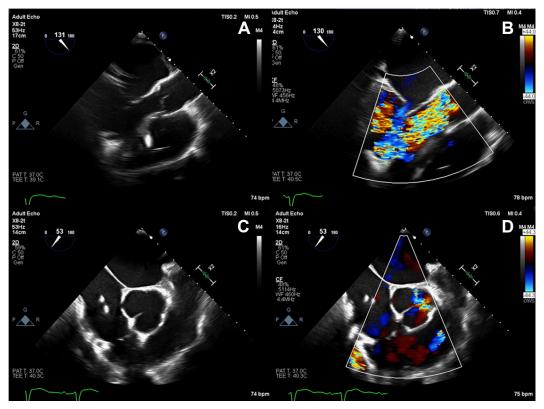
Two-dimensional TEE, midesophageal long-axis (*top row*) and short-axis (*bottom row*) views in diastole, without (*left*) and with (*right*) color-flow Doppler, demonstrates appropriate LVAD inflow cannula position (A), severe AR (B), poorly visualized aortic leaflets (C), and lack of coaptation along the edge of the left coronary cusp (D).
